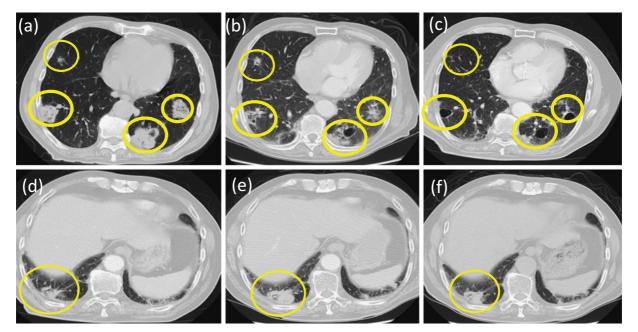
(a) Chest CT scan before chemotherapy. (b) After one course of chemotherapy, the chest CT scan showed a 63.6% unidimensional reduction in the size of the lung nodules. (c, d) A chest CT scan revealed no reduction in their size of the lung nodules one month after 5 cycles of therapy. (e) The lung nodules located in the lower lobe had again progressed 5 months after 5 cycles of therapy. (f) The size of the lung nodules was reduced on the chest CT scan 1 month after 7 cycles of therapy. Yellow circles show metastatic lesions in the lung.
